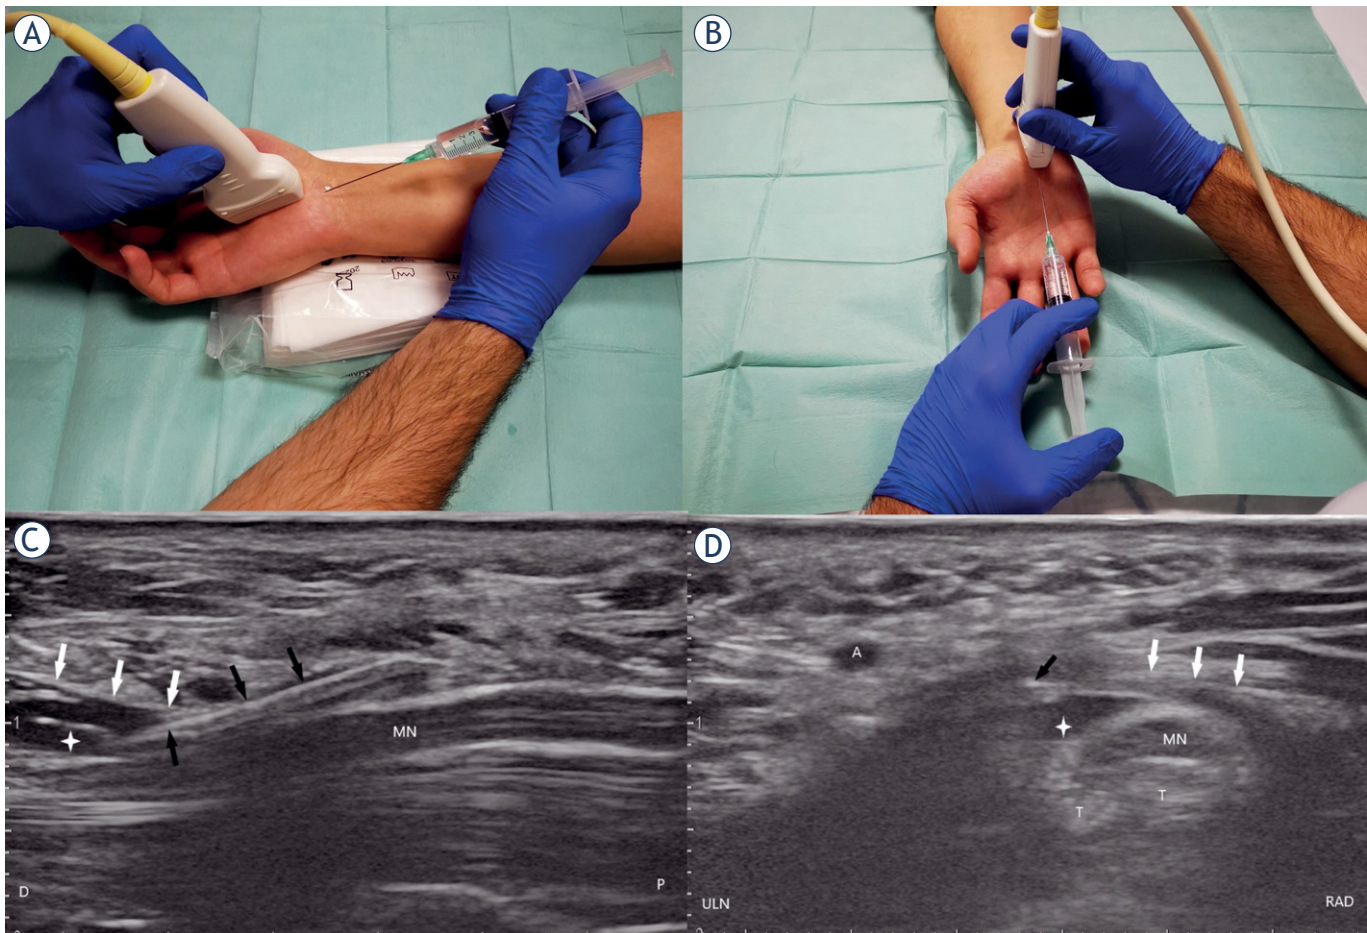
(A), (B), (C), and (D) showing the longitudinal approach. (A) Wrist and needle positioning for carpal tunnel injection for the proximal to distal approach, (B) Wrist and needle positioning for carpal tunnel injection for the distal to proximal approach, (C) Ultrasound of the carpal tunnel shown in the long axis after the needle penetrates the transverse carpal ligament and positioning the needle tip parallel to the median nerve, (D) ultrasound of the carpal tunnel shown in the short axis after the needle penetrates the transverse carpal ligament positioning the needle tip parallel to the median nerve. Note in C and D the expanded perineural space marked with a white cross.
